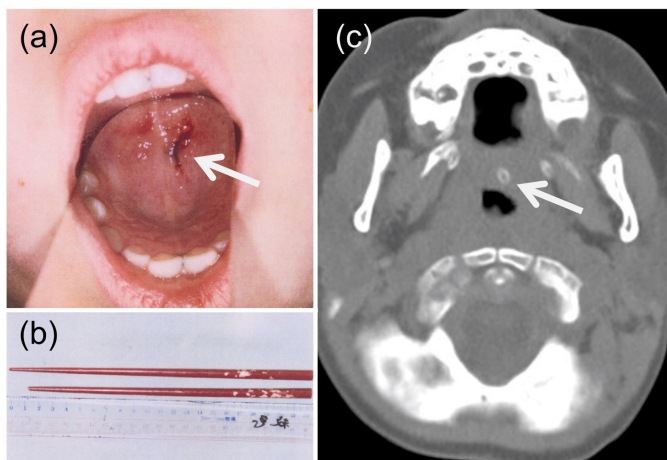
Three-year-old boy with transoral chopstick penetration injury (a) Photograph of the oral cavity. Laceration and small amount of bleeding on the soft palate (arrow). Chopstick is not visible. (b) A broken chopstick and an unbroken chopstick. The broken chopstick was approximately 1 cm shorter than the other unbroken chopstick. (c) A non-contrast-enhanced CT image of the soft palate shows a ring-shaped dense lesion (arrow), consistent with a broken chopstick
